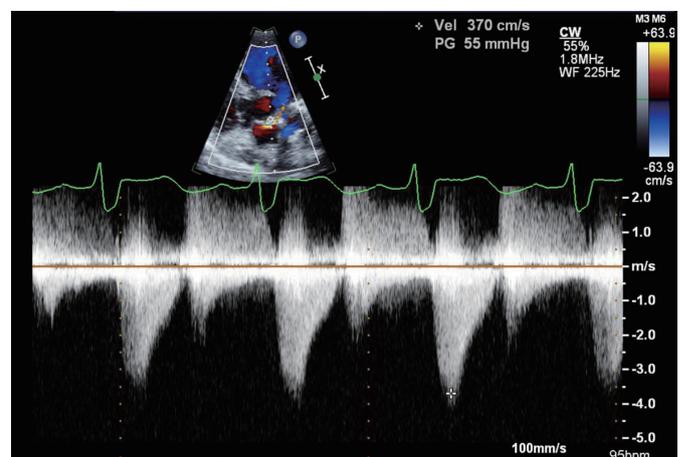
Transthoracic echocardiography with continuous wave Doppler study revealed significant left ventricular outflow tract obstructions with pressure gradients of 55 mm Hg.
